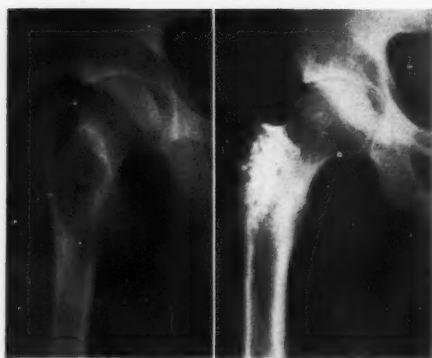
Case 14: Giant-cell tumor of greater trochanter of right femur before and ten years after curettage and roentgen therapy.
